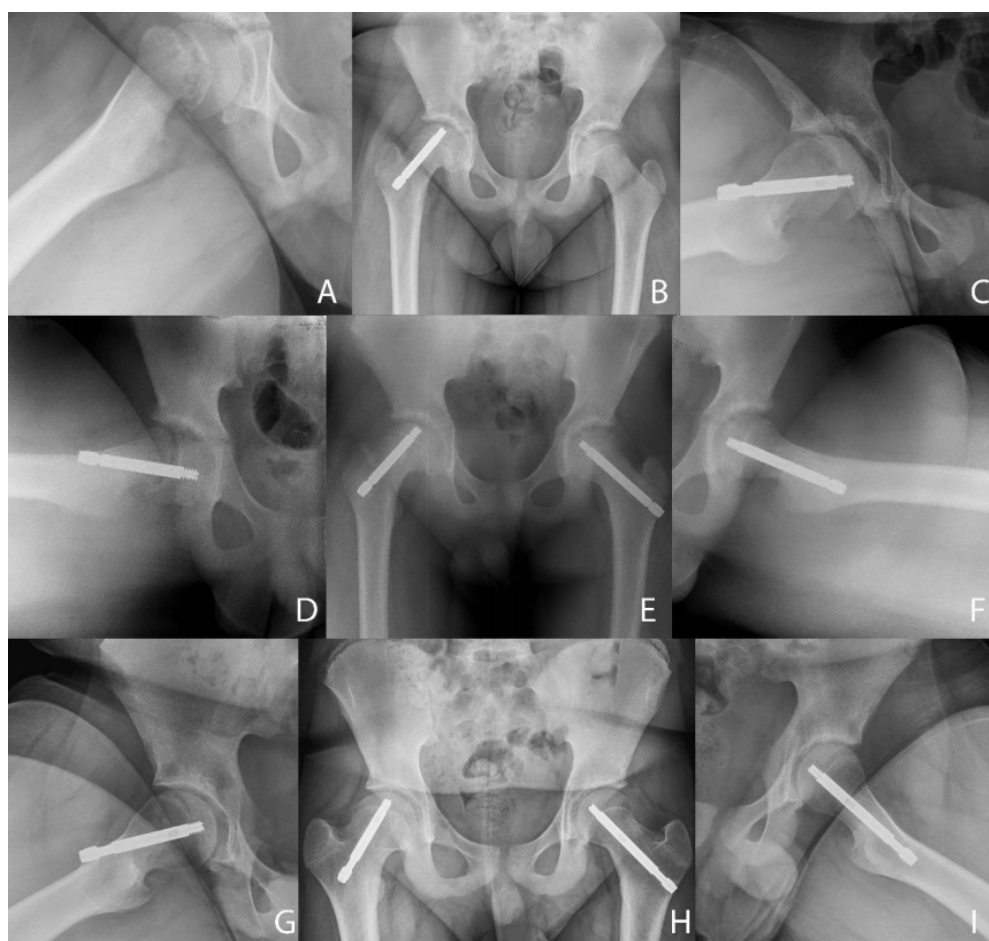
A) preoperative moderate SCFE frog leg view; B) postoperative radiograph; C) 12 postoperatively; D) left hip 5 months following prophylactic pinning; E) AP view 5 months after prophylactic pinning; F) right hip 5 months following prophylactic pinning; G) right hip last check-up frog-leg view; H) AP both hips 18 months after surgery; I) screw elongation in prophylactic pinning 18 months follow-up.
